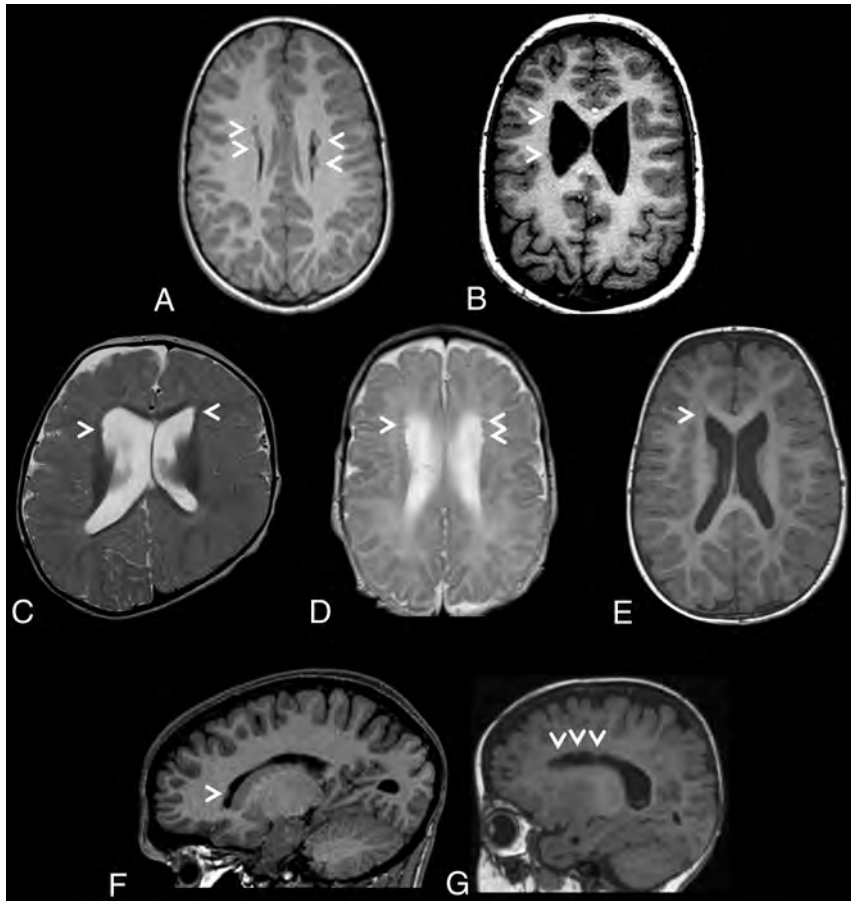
Brain MR images depicting periventricular nodular heterotopia distributions in a cohort of 7 unrelated individuals with ZTTK syndrome. A, Axial T1-weighted MRI of the brain of individual 1 at 7 years 7 months of age revealing sparse bilateral frontal heterotopia (white arrowheads). B, Axial T1-weighted MRI of the brain of individual 2 at 11 years and 6 months of age revealing sparse right unilateral frontal and midbody heterotopia (white arrowheads). C, Axial T2-weighted MRI of the brain of individual 3 at 1 year of age revealing sparse bilateral frontal horn heterotopia (white arrowheads). D, Axial T2-weighted MRI of the brain of individual 4 at 1 year 4 months of age revealing sparse bilateral frontal horn heterotopia (white arrowheads). E, Axial T1-weighted MRI of the brain of individual 5 at 1 year 8 months of age revealing a heterotopion of the right frontal horn (white arrowhead). F, Right parasagittal T1-weighted MRI of the brain of individual 6 at 15 years 2 months of age revealing a heterotopion of the right frontal horn (white arrowhead). G, Left parasagittal T1-weighted MRI of the brain of individual 7 at 1 year 2 months of age revealing sparse left frontal horn heterotopia (white arrowheads).
